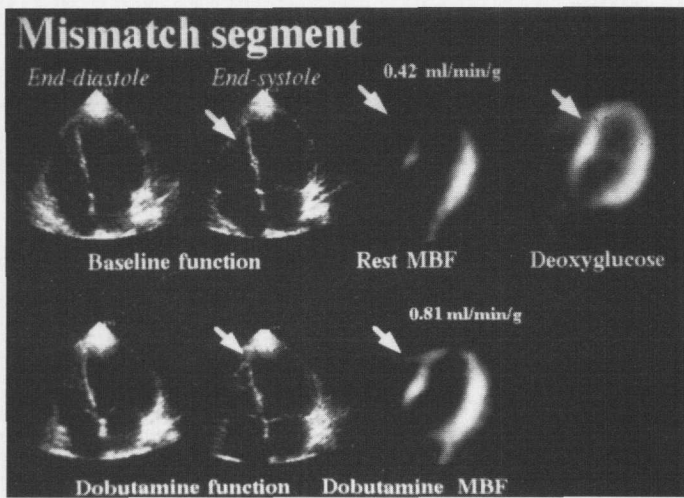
Echocardiographic and tomographic findings in myocardial hibernation. The analysis of baseline wall motion (top left) shows septal akinesia not improving during dobutamine (bottom left). PET study (right panels) revealed that the septal dysfunction was associated with a reduced perfusion (resting MBF) and preserved deoxyglucose uptake raising the picture of hibernating myocardium. Despite the lack of contractile response, dobutamine increased significantly regional MBF.
